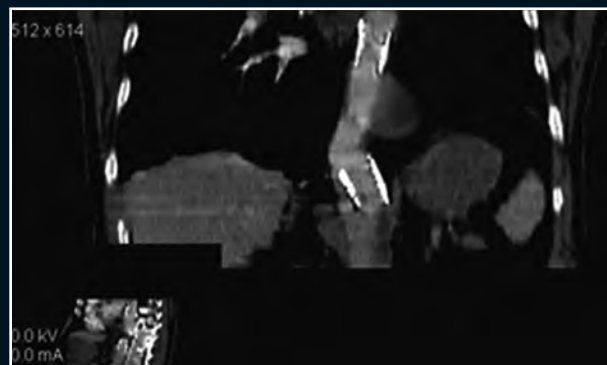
CT scan of Patient B ten years after stent-grafting.
